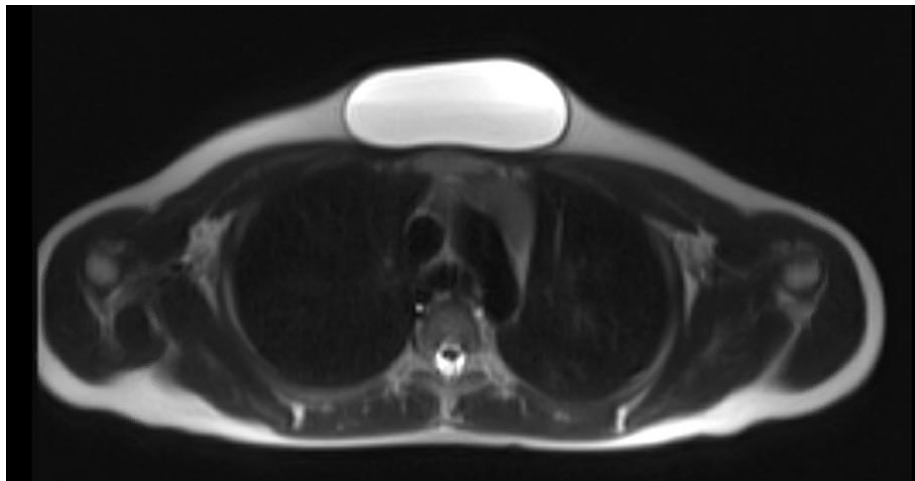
MRI Scan confirming a unilocular fluid filled lesion in presternal soft tissue with no internal connection.
